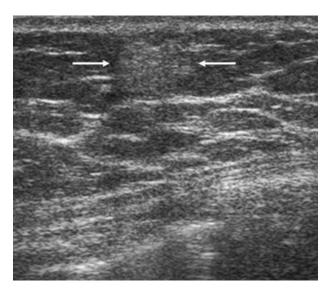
Ultrasound pitfall: angiosarcoma mistaken for a lipoma.
